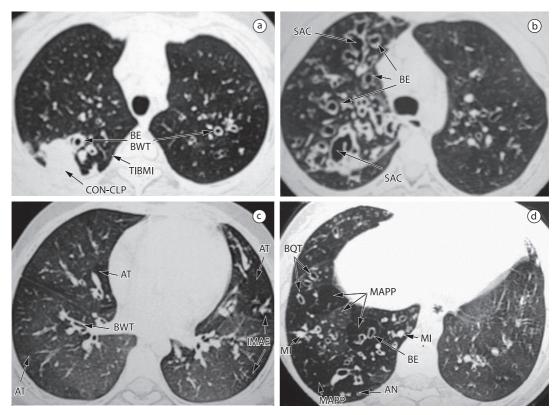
HRCT scans. In A, presence of bronchiectasis (BE), bronchial wall thickening (BWT), tree-in-bud mucoid impaction (TIBMI), and consolidation/collapse (CON-CLP). In B, presence of BE and sacculations (SAC). In C, presence of BWT and air trapping (AT). In D, presence of BE, mucoid impaction (MI), mosaic attenuation/perfusion pattern (MAPP), and acinar nodule (AN).
